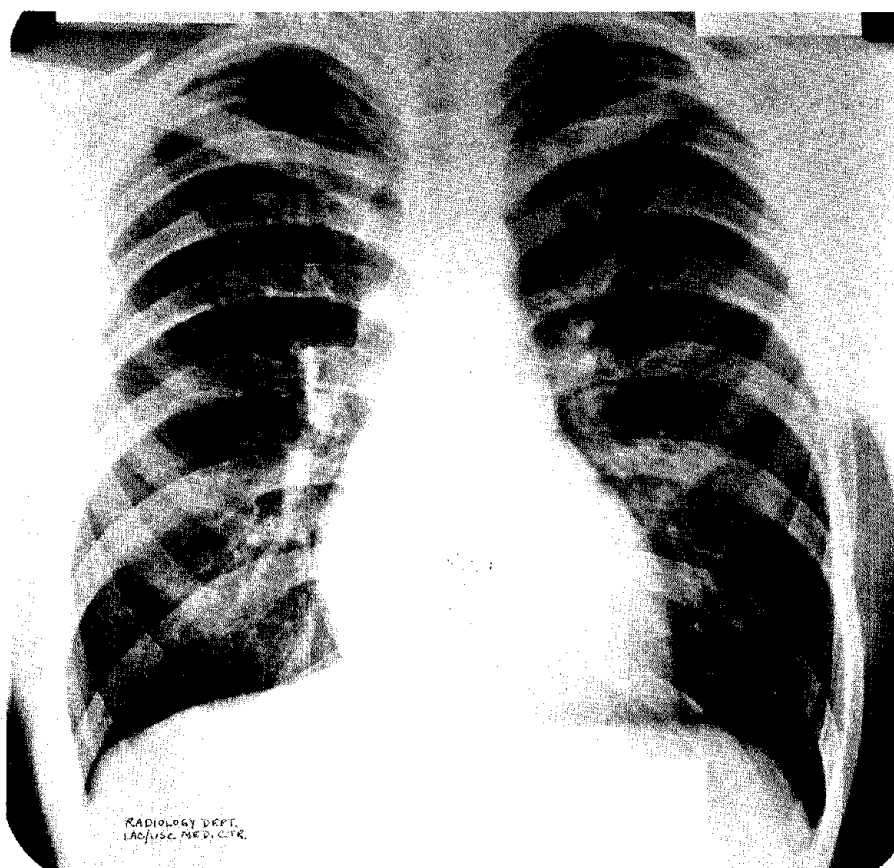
Normal chest radiograph. There is good visualization of the blood vessels throughout both lungs with faint visualization through the heart shadow. This film includes both costophrenic angles and the apices of the lung. The patient is in deep full inspiration. The costopleural margins are well outlined with no obscuration from the overlying scapulae. The patient and x-ray beam are properly aligned to the cassette.
